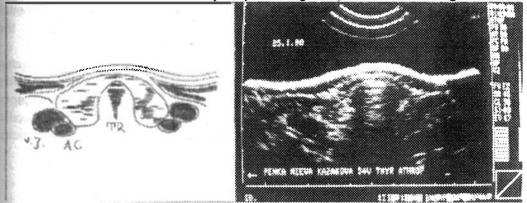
Ultrasonographic image in a patient with Hashimoto thyroiditis
